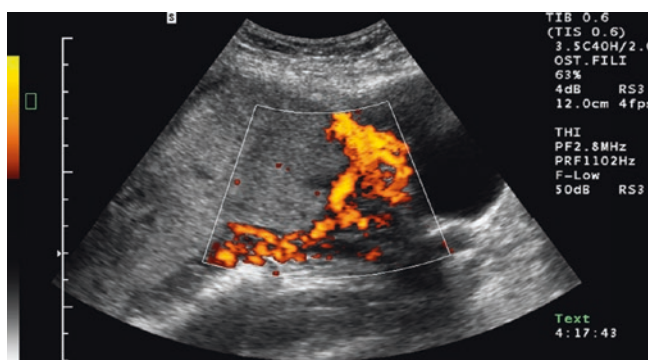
Placenta previa accreta – abnormalities of the uterine serosa–bladder interface with increased vascularity on color Doppler imaging
